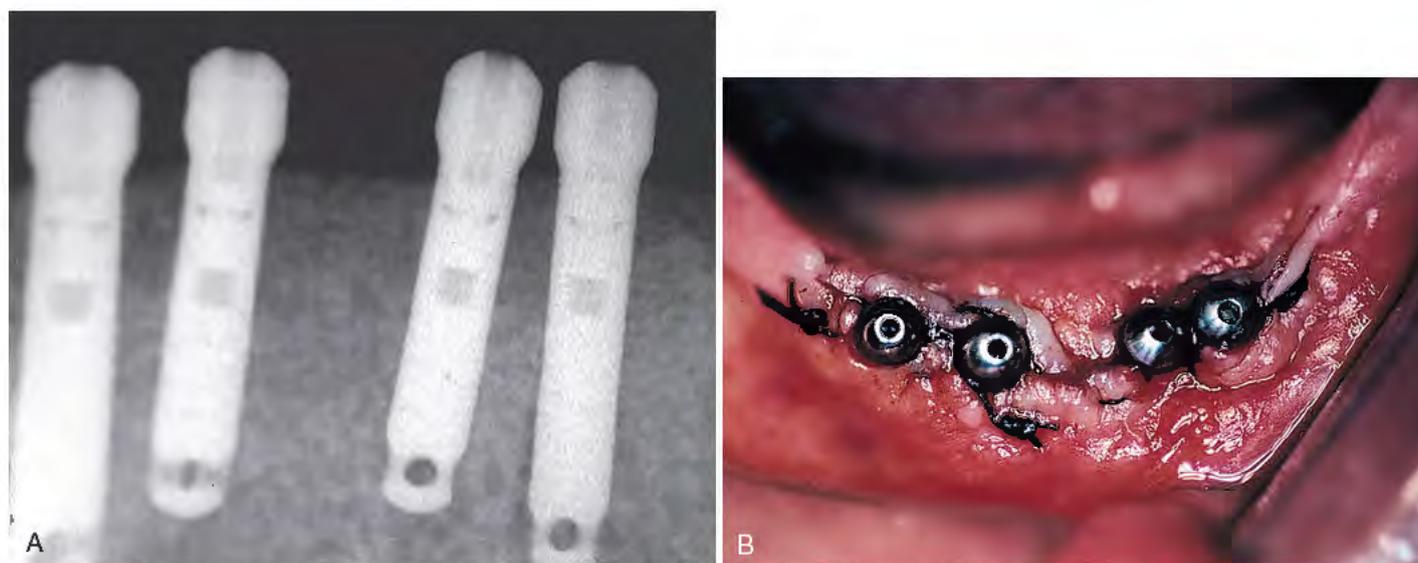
A, After healing collars have been placed, complete seating is verified with a periapical radiograph. B, When the position of the collars is assured, the flaps are scalloped to accommodate the implants and then sutured closed.
